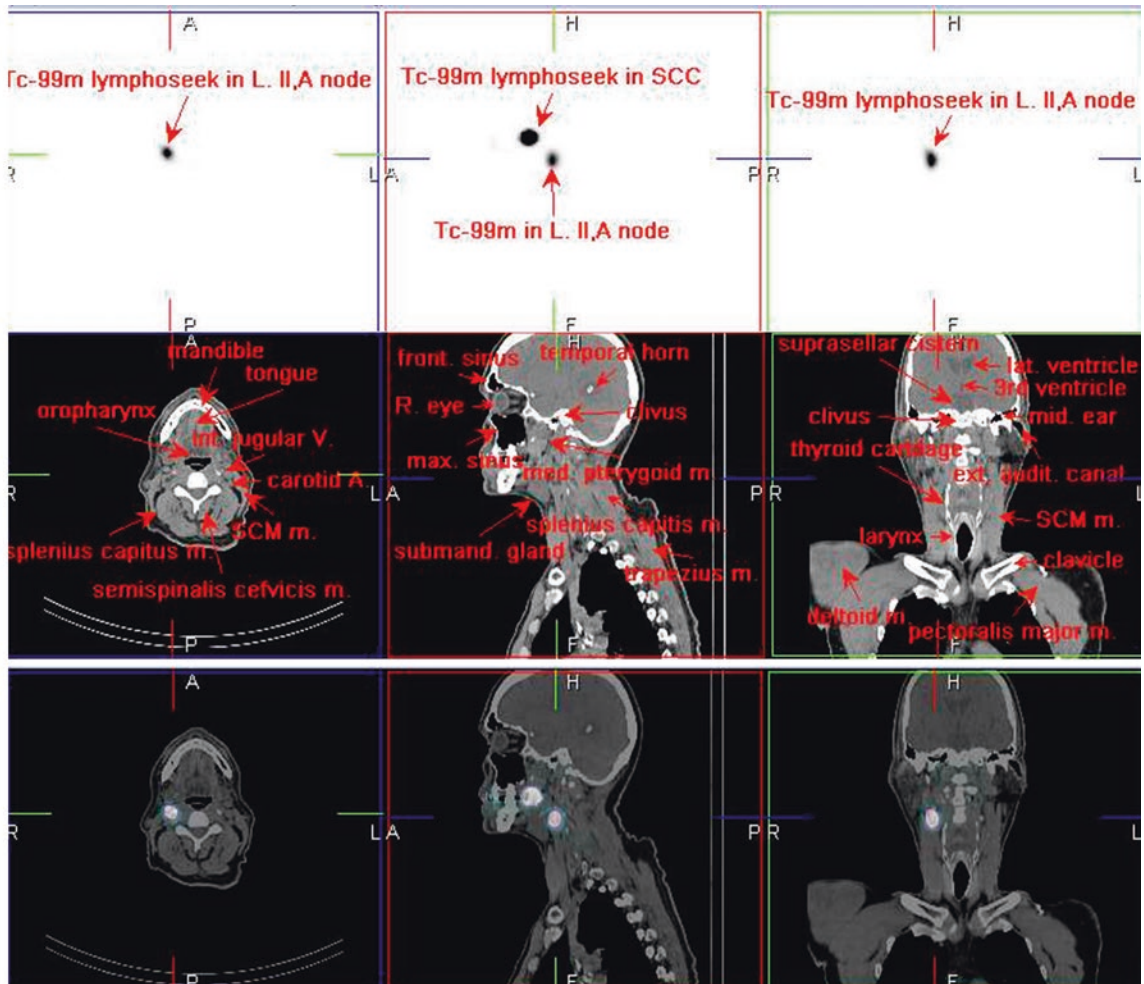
^{99m}Tc -lymphoseek SPECT/CT
